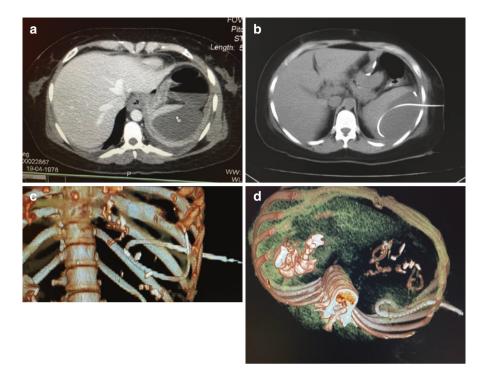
(a-d) Sequence and drainage under CT scan guidance of a big abscess after sleeve gastrectomy
